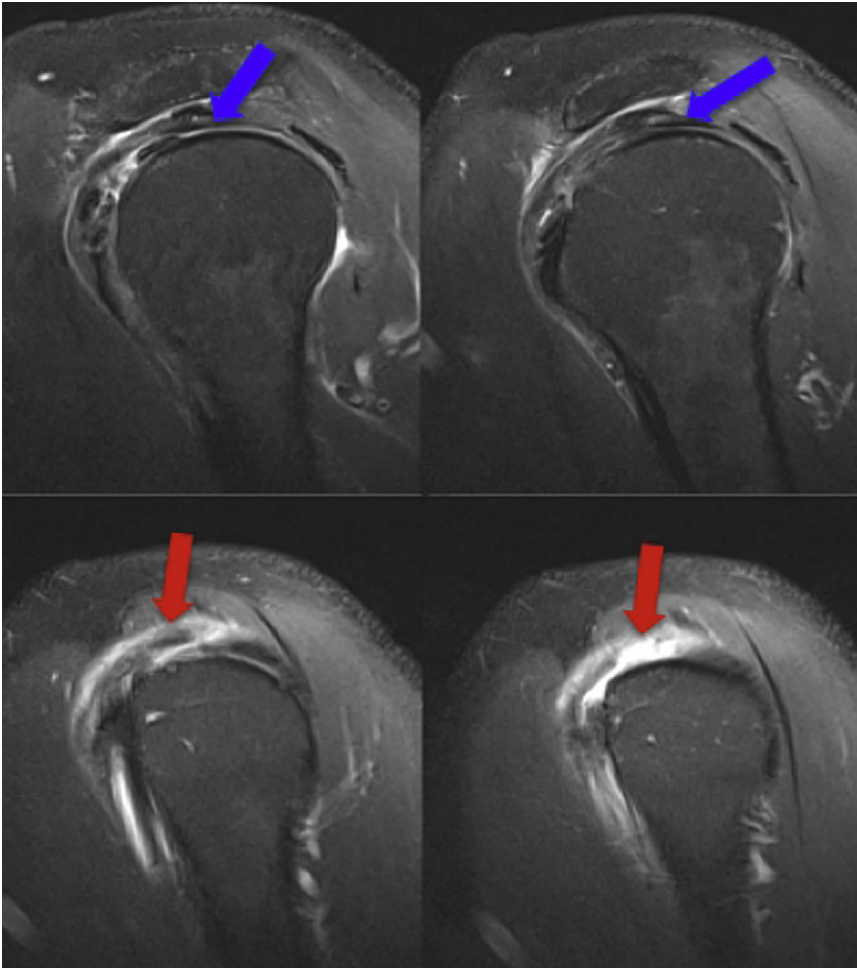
Crescent-shaped tear, sagittal oblique plane. Multiple consecutive sagittal oblique fat-suppressed T2-weighted images of the right shoulder in the same patient as in Fig. 12 demonstrates a crescent-shaped full-thickness tear at the junction of the supraspinatus and infraspinatus tendons (*red arrows*). The coracohumeral ligament arises from the coracoid process and extends along the undersurface of the supraspinatus and infraspinatus tendons as the rotator cable (*blue arrows*).
